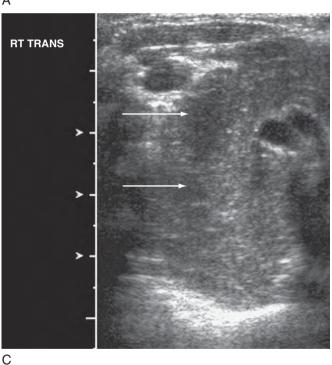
Utility of ultrasound imaging: infant status post surgery for congenital heart disease. Radiograph (A) prior to discharge demonstrates a normal mediastinum. Subsequent radiograph (B) 6 months later demonstrates a widened mediastinum. Ultrasound (C) demonstrates this to be due to rebound of normal thymic tissue (arrows).
